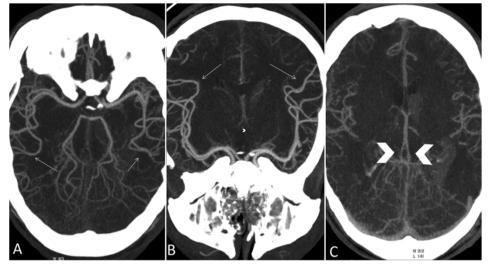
CTA targets were the distal MCA segments (arrows in A and B) and ICVs (arrowheads in C).
